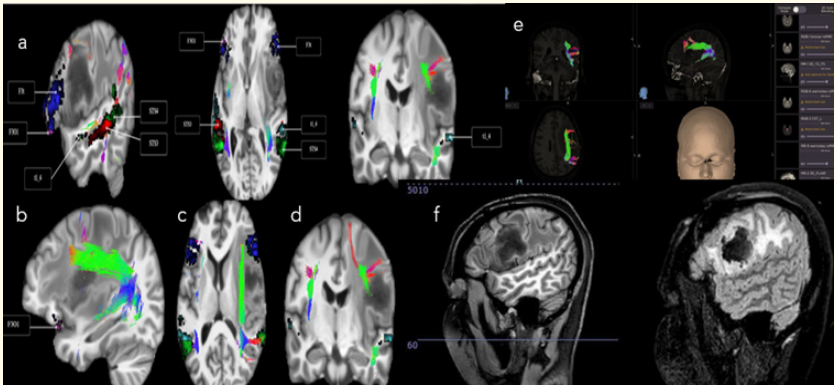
a- language parcellations, b,c- AF, d- FAT, e- Neuronavigation integration, f- Pre and post operative MRI images showing gross total excision.
